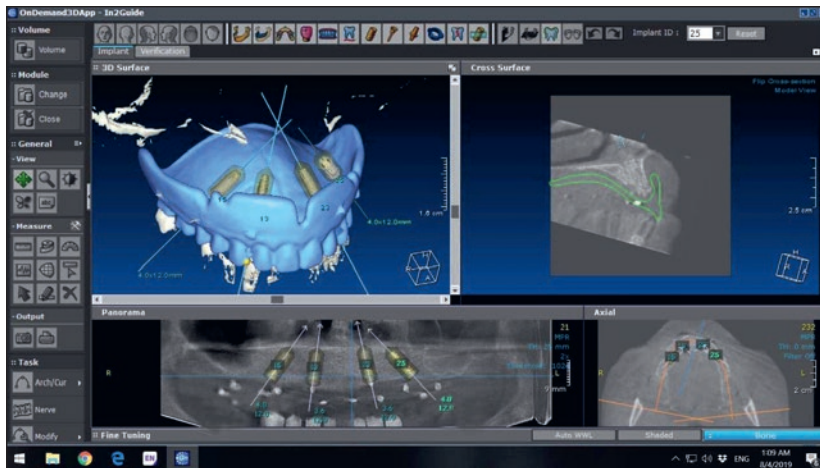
Planning of the implants using the CBCT software.
